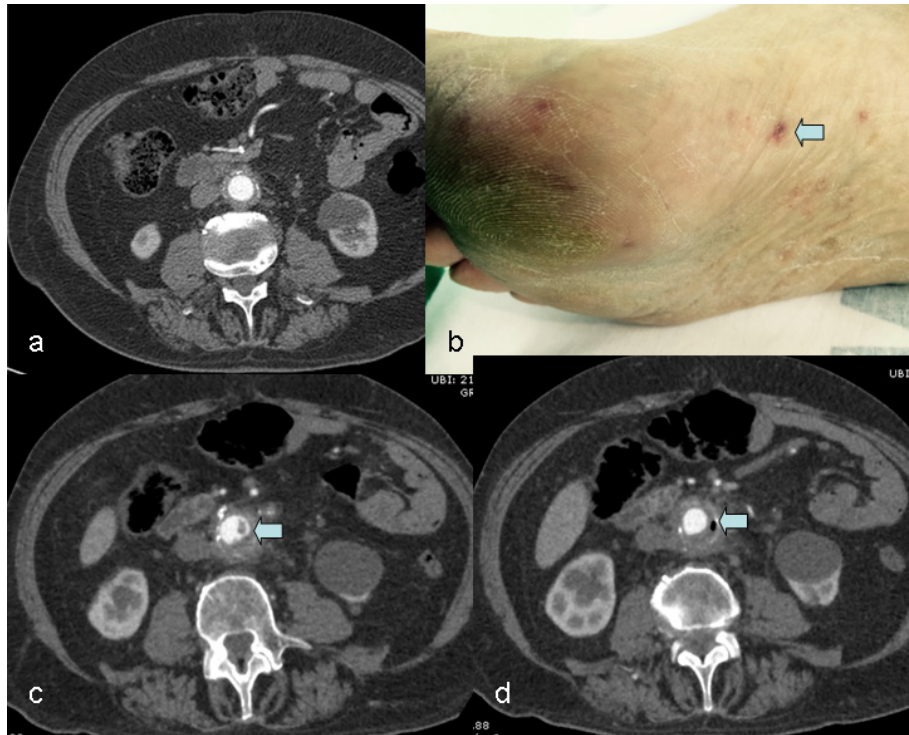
A: Shows early CT-scan with normal aortic graft after first re-intervention. B: The image exhibits characteristic foot lesions of embolic events (arrow). C: Image shows thrombus inside the graft (arrow). D: The image shows gas inside the aortic graft (arrow).
